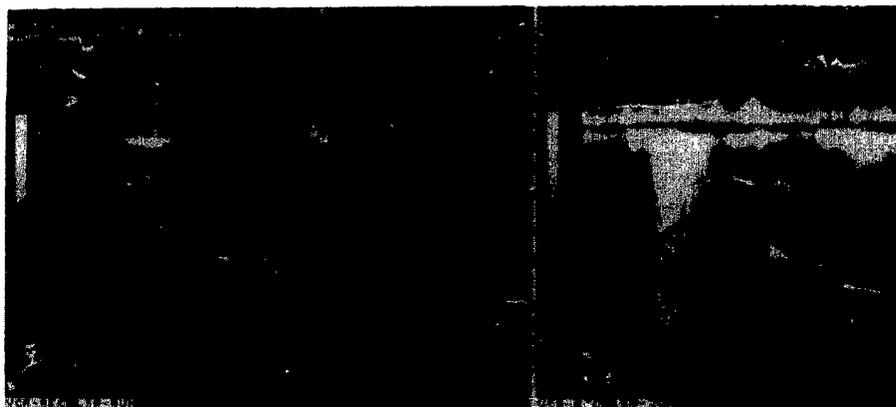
Original continuous wave Doppler of anterograde aortic flow velocities in a patient with aortic stenosis. Left, Baseline recording had a vague envelope. Right, Contrast enhancement provided a clear envelope and allowed confident measurement of peak velocity.
